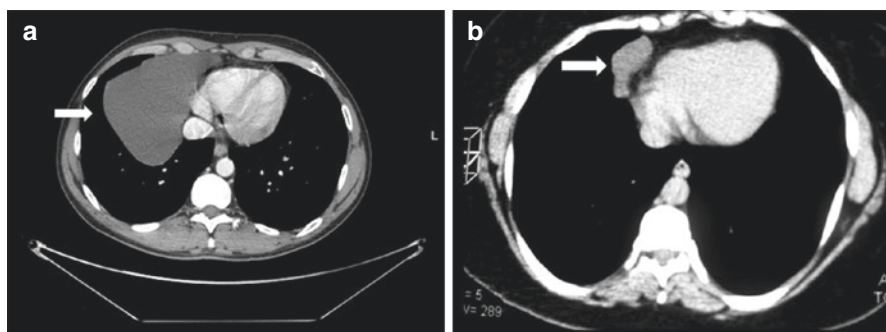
Contrast-enhanced computed tomography images of the thorax showing a 15 × 10 cm (a) and a 6 × 7 cm (b) well-defined homogenous cystic lesions (white arrow)
